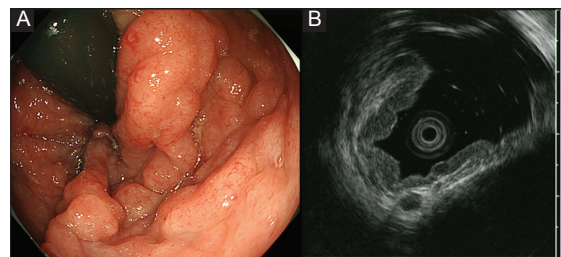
(A) Colonoscopy showed submucosal tumors of multiple and variable size in the lower rectum, with a worm-like shape. (B) Endoscopic ultrasound revealed homogeneous, hypoechoic thickening of the *lamina propria* with a clear border from the submucosal layer
